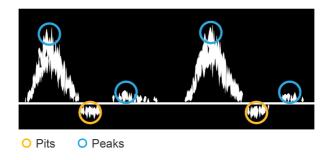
Triphasic waveforms on duplex ultrasound consist of two peaks and one pit.
